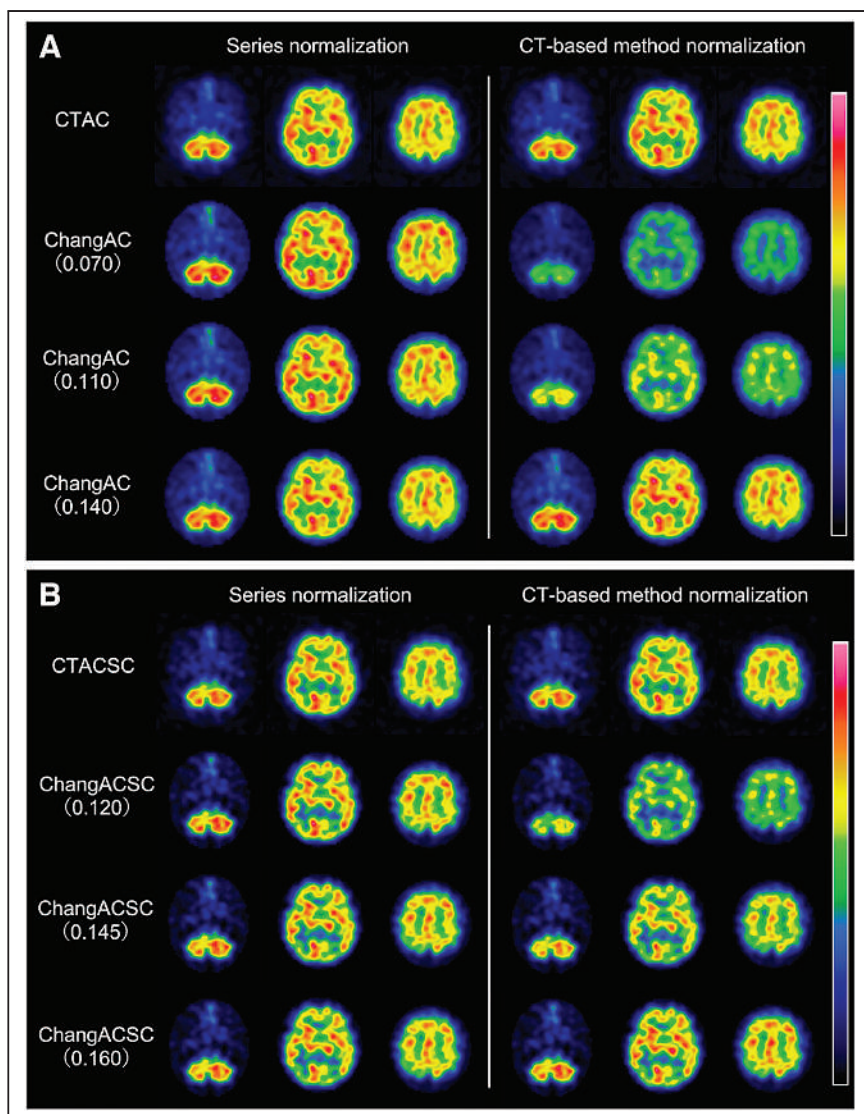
Comparison of SPECT images of CTAC and ChangAC (A) and CTACSC and ChangACSC (B) in 1 reference patient. For ChangAC, μ -values of 0.07, 0.110, and 0.140 were applied; for ChangACSC, μ -values of 0.12, 0.145, and 0.160 were applied. On left are SPECT images normalized by maximum counts in series; on right are SPECT images normalized by maximum counts of CT-based method. From left to right, axial slices are at cerebellar, basal ganglia, and parietal levels.
